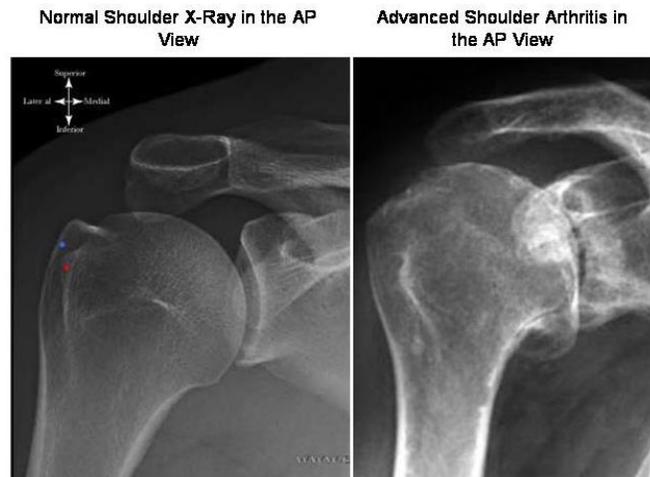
X-ray imaging showing the degenerative changes at the shoulder. (Image via Boston Shoulder Institute)
